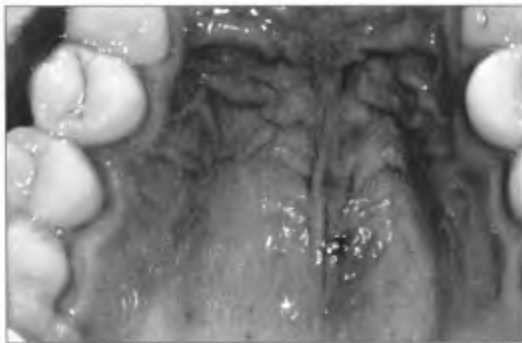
16 Orientation pin in hard palate. The pre-operative X-ray indicates an inappropriate position for insertion. The arrow indicates a more suitable position.
